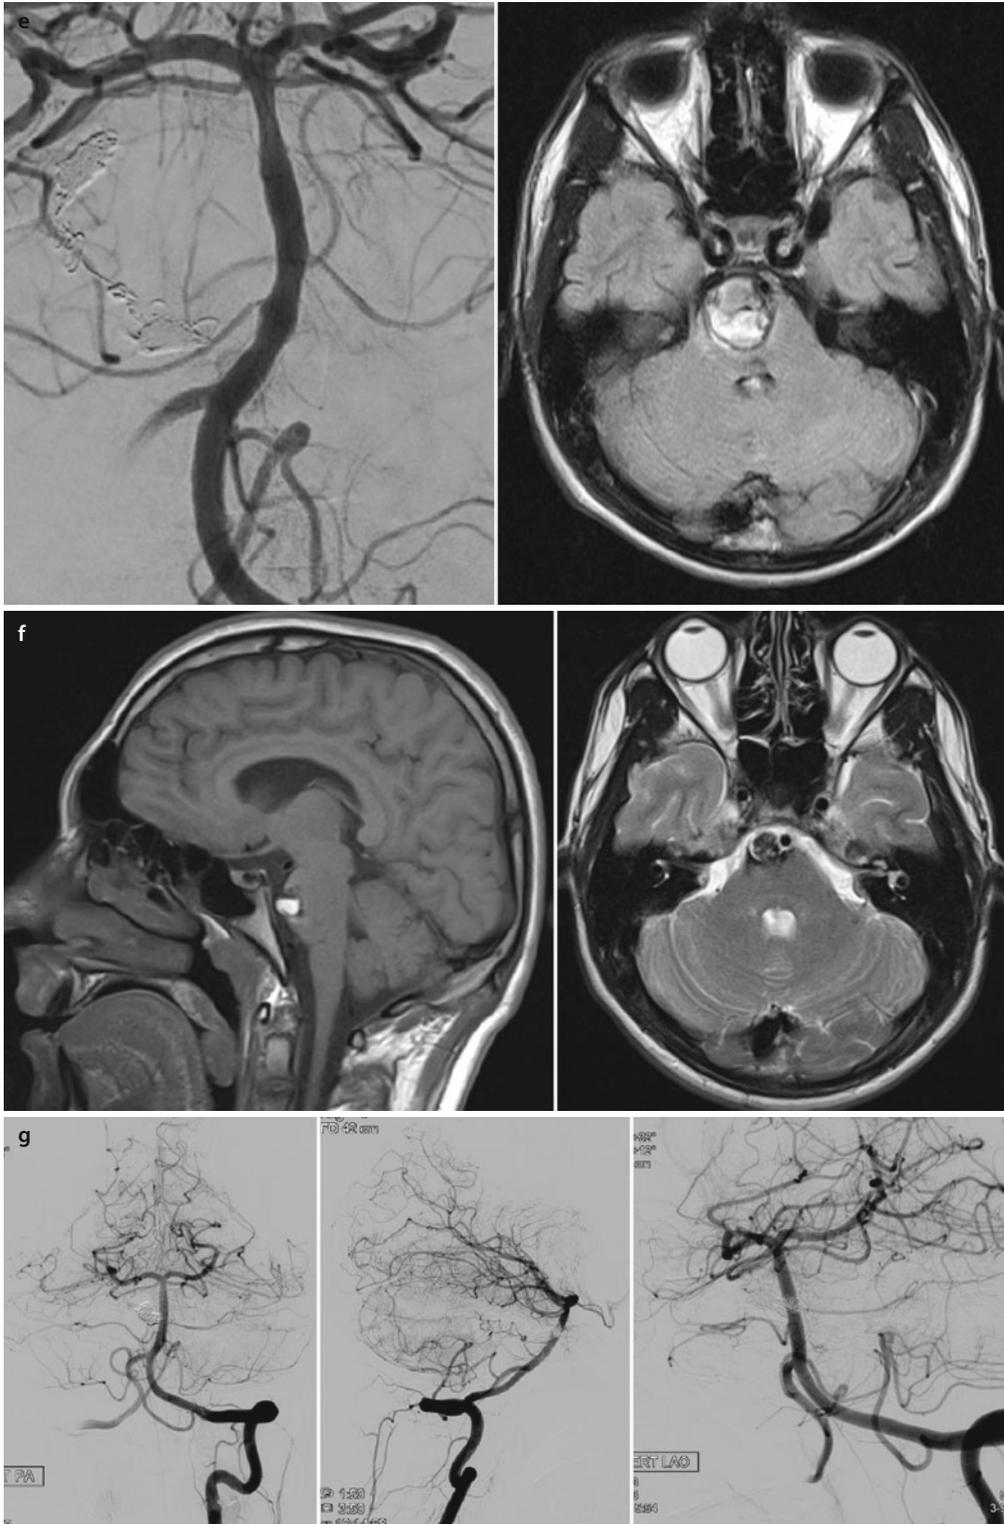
A 17-year-old man presented with severe headache. (a) On September 2013, Fisher grade 1 acute SAH on NECT with a GCS 15. Cerebral DSA reveals a mid-basilar aneurysm suggestive of underlying dissection. The patient was treated with balloon-assisted coiling. As there was strong suspicion of an underlying dissection, the patient was planned for interval basilar stenting after 2 weeks. (b) The patient underwent a control DSA after 18 days. There was aneurysmal neck recanalization. The patient was re-treated with balloon-assisted coiling followed by FRED® FD deployment. (c) After 2 months, the patient presented with features of brain stem compression and edema. NECT and MRI images of the brain stem reveal a well-defined mixed intensity mass lesion compressing the pons. There is adjacent peri-aneurysmal vasogenic edema.
